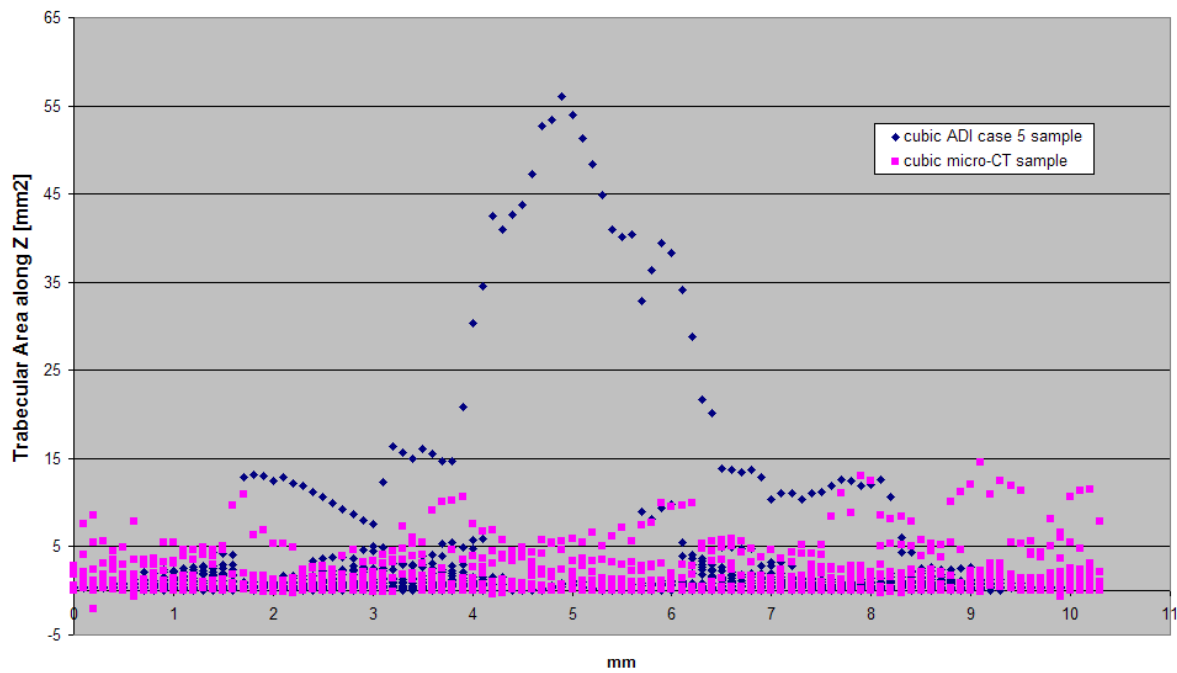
Comparison of sliced area along Z between the cubic ADI case 5 sample and cubic  $\mu$ CT sample
